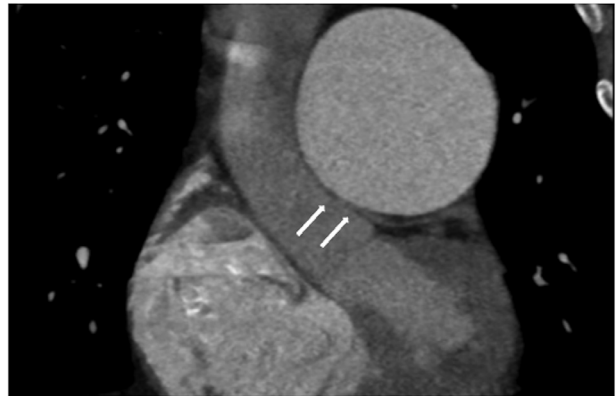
Computed tomography. Large PA Aneurysm. White arrows show LMCA external compression by PA aneurysm. LMCA: left main coronary artery; PA: pulmonary artery.
